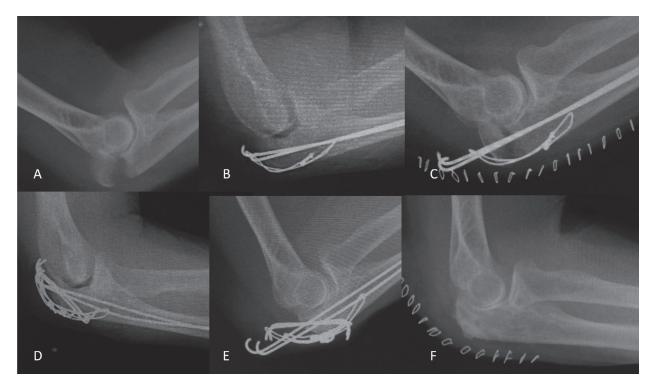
An 84-year-old elderly female with type II A fracture. A, Preoperative X-ray. B, Immediate postoperative X-ray. C, One month postoperative X-ray. D, Immediate post-reoperation X-ray. E, Two weeks post-reoperation X-ray. F, Final follow-up X-ray.
